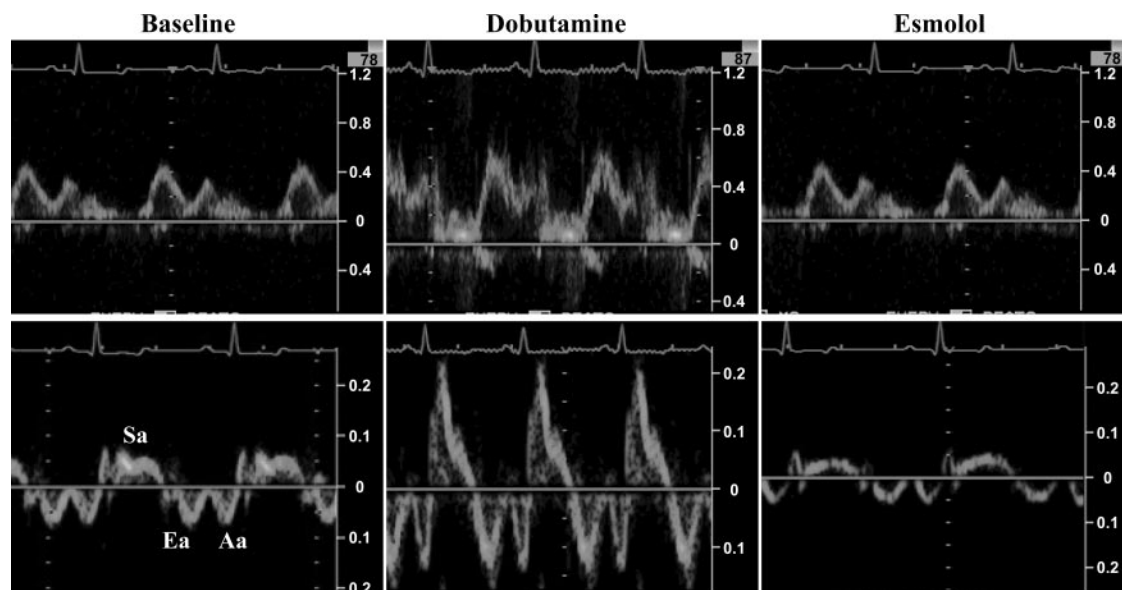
Representative recordings of the lateral tricuspid annular motion velocity using tissue Doppler imaging (TDI) at baseline (left), with dobutamine (middle), and with esmolol (right). Ea, ventricular early diastolic velocity; Aa, ventricular late diastolic velocity.
